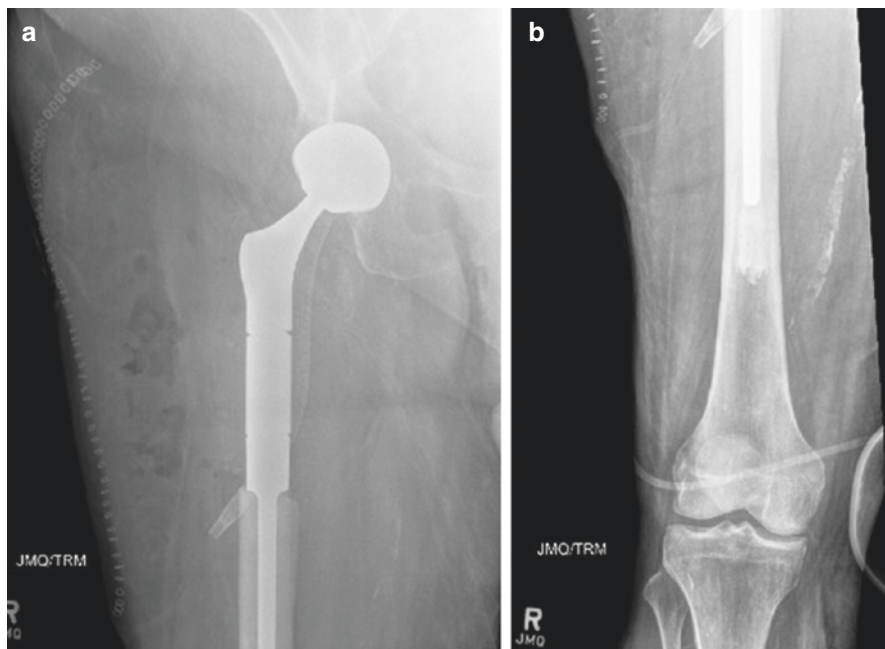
AP and lateral radiographs of a cemented proximal femoral replacement performed for pathologic fracture
